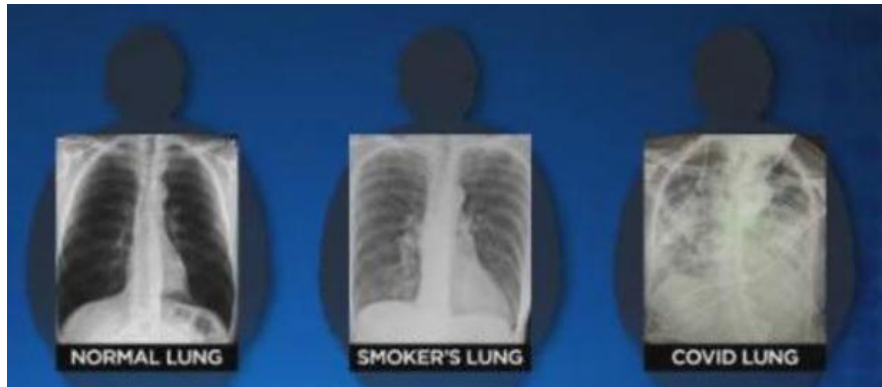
X-rays of a normal lung, a smoker's lung and a COVID patient's lung [26, 1]
